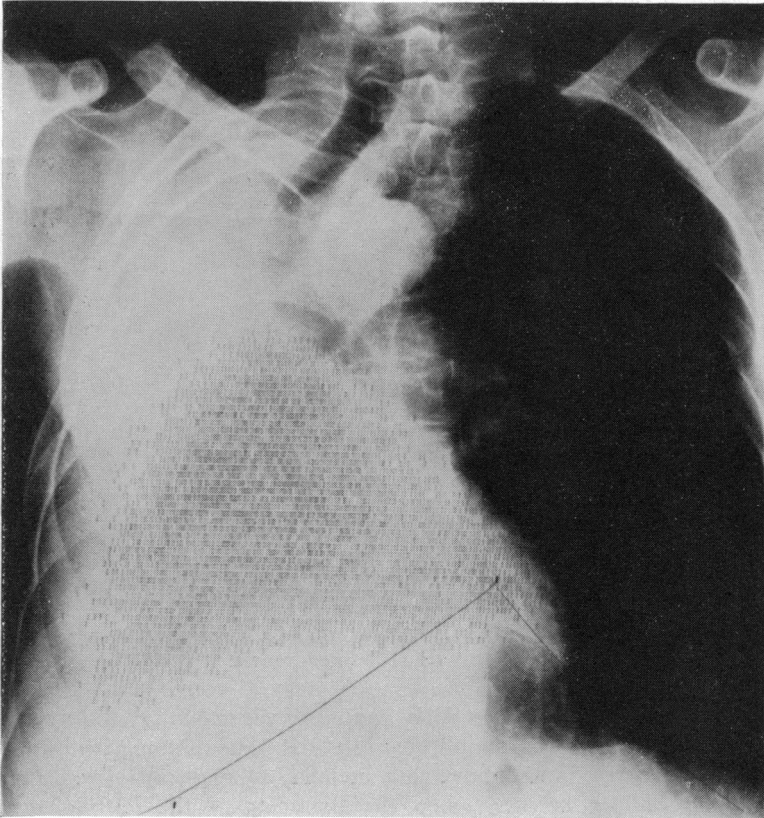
Chest plate and liver scintigram after pneumonectomy.
